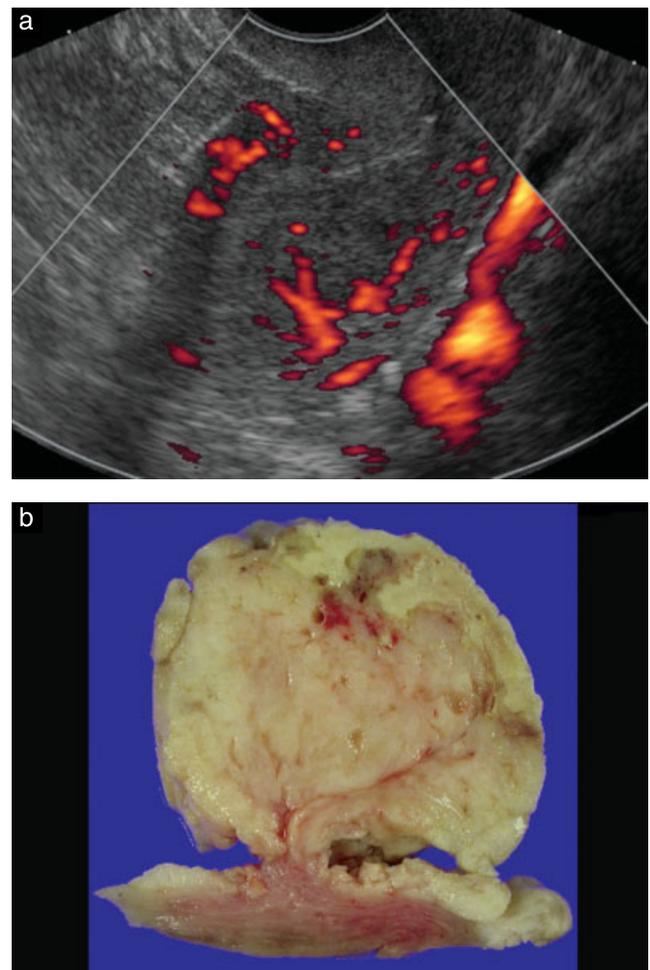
Malignant mixed Müllerian tumor in a 57-year-old woman. (a) Sagittal color Doppler image of the uterus showing a single feeding vessel at the base of the tumor. (b) Cut surface of the resected tumor showing a large feeding vessel, which entered through the pedicle, and branching small vessels within the mass.
